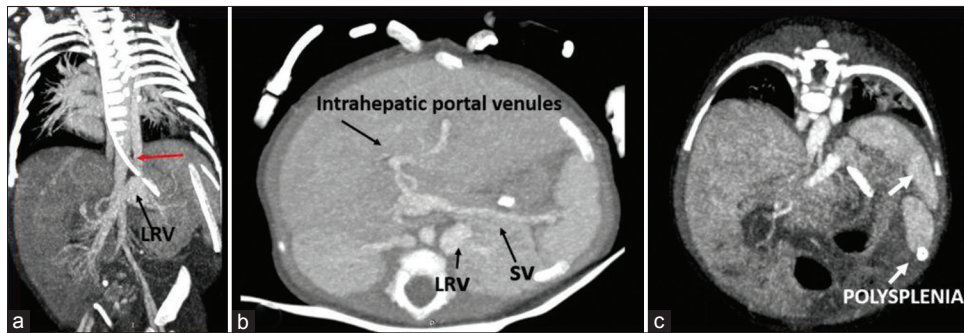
(a) Contrast-enhanced computed tomography abdomen coronal image showing left renal vein draining into Hemiazygous vein (red arrow). (b) Same image in an axial cut showing splenic vein draining into the left renal vein. (c) Oblique coronal cut showing polysplenia (white arrows)
